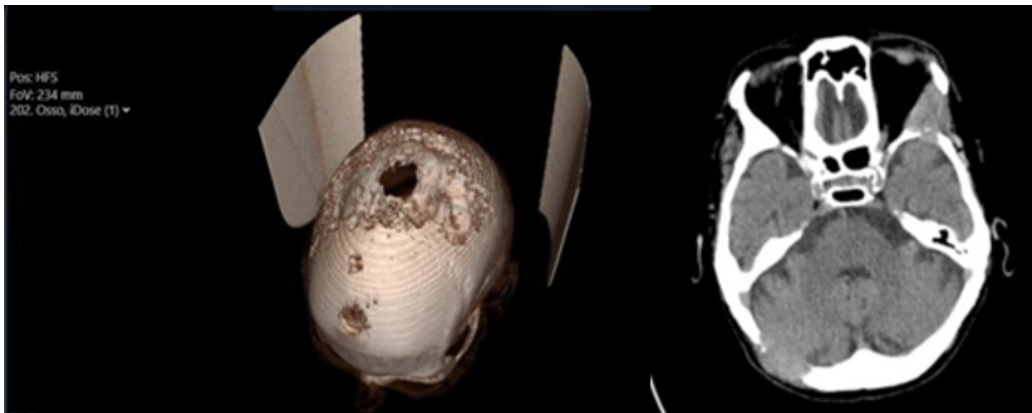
(A and B) – Head CT scan showing extensive and infiltrative lytic lesion – tridimensional reconstitution and transverse plane respectively.
